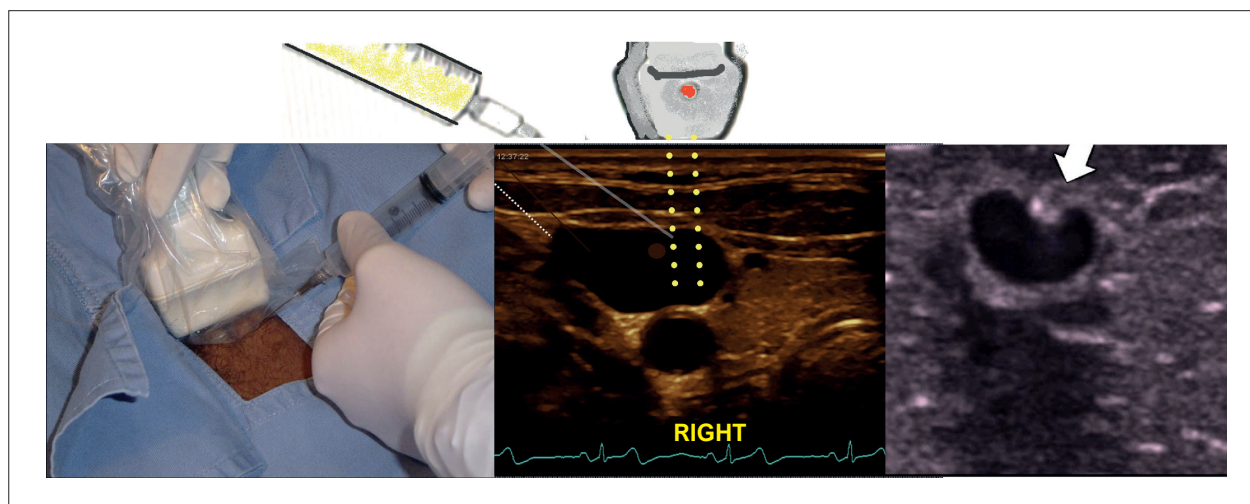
Needle positioning and orientation in the transverse cannulation technique. The needle can be visualized only as an echogenic dot when crossing the ultrasound beam. Movement of the surrounding tissues helps identify needle location, and indentation of the venous wall confirms correct positioning.
